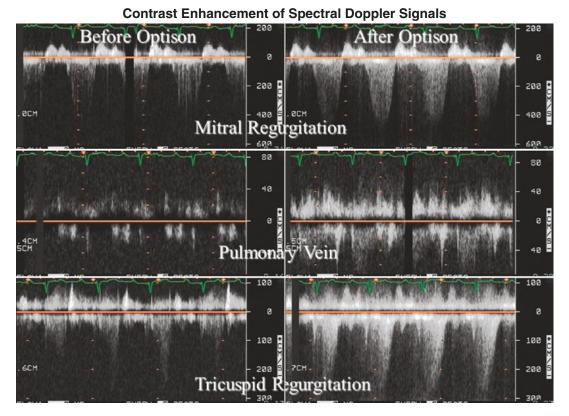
Enhancement of spectral Doppler recordings using the Contrast agent Optison. This was obtained at the end of a conventional LVO contrast study when very little
